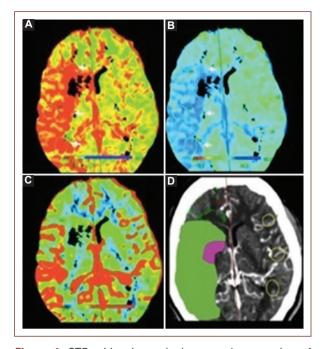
CTP with mismatch due to a large region of ischemic penumbra (salvageable hypoperfused tissue), compared to the ischemic core (unsalvageable tissue). A: CBF map shows a region of decreased perfusion within the right MCA territory (white arrowheads). B: median transit time map shows an increased blood contrast time that matches the same region as (white arrowheads). C: CBV map demonstrates no abnormality. D: large ischemic penumbra (green) with a small ischemic core (purple), representing a CTP mismatch. CBF: cerebral blood flow; CBV: cerebral blood volume; CTP: computed tomography perfusion; MCA: middle cerebral artery; MTT: median transit time.
